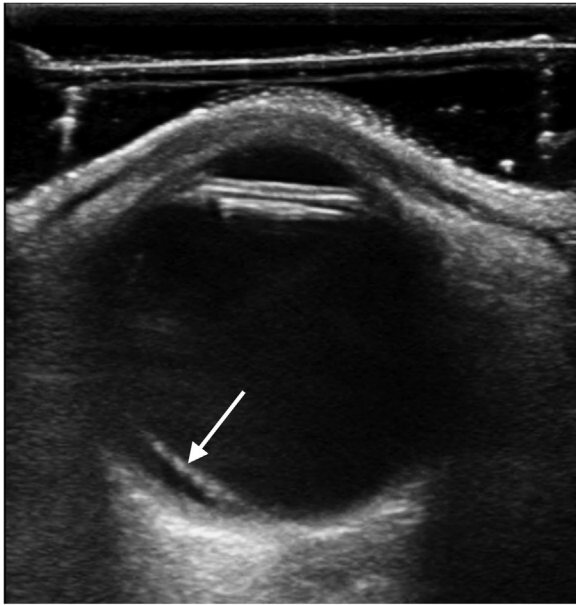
Point-of-care ultrasound (POCUS) demonstrating retinal detachment (white arrow). Courtesy of Dr. Michael Gottlieb.
